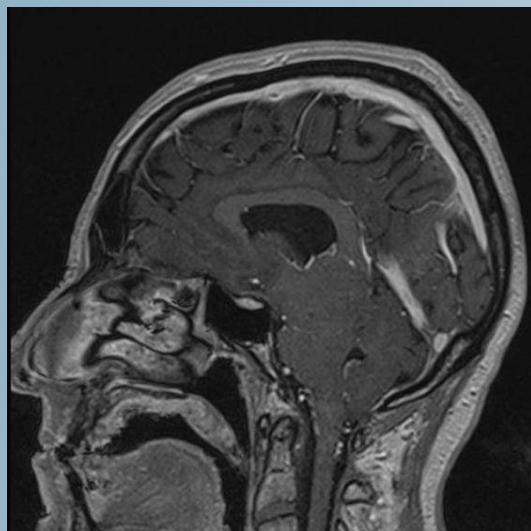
Sagittal T1 gad+ sequence MRI showing a small posterior fossa results in crowding of hindbrain structures, producing downward herniation of cerebellar tonsil of 7 mm
